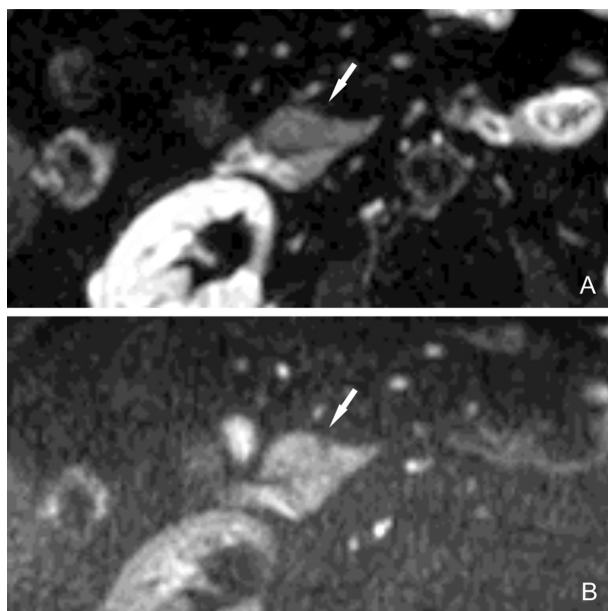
MRI follow-up one month later shows negative findings in diffusion weighted sequences with b100 (A) and b800 value (B), indicating acute phase resolution
